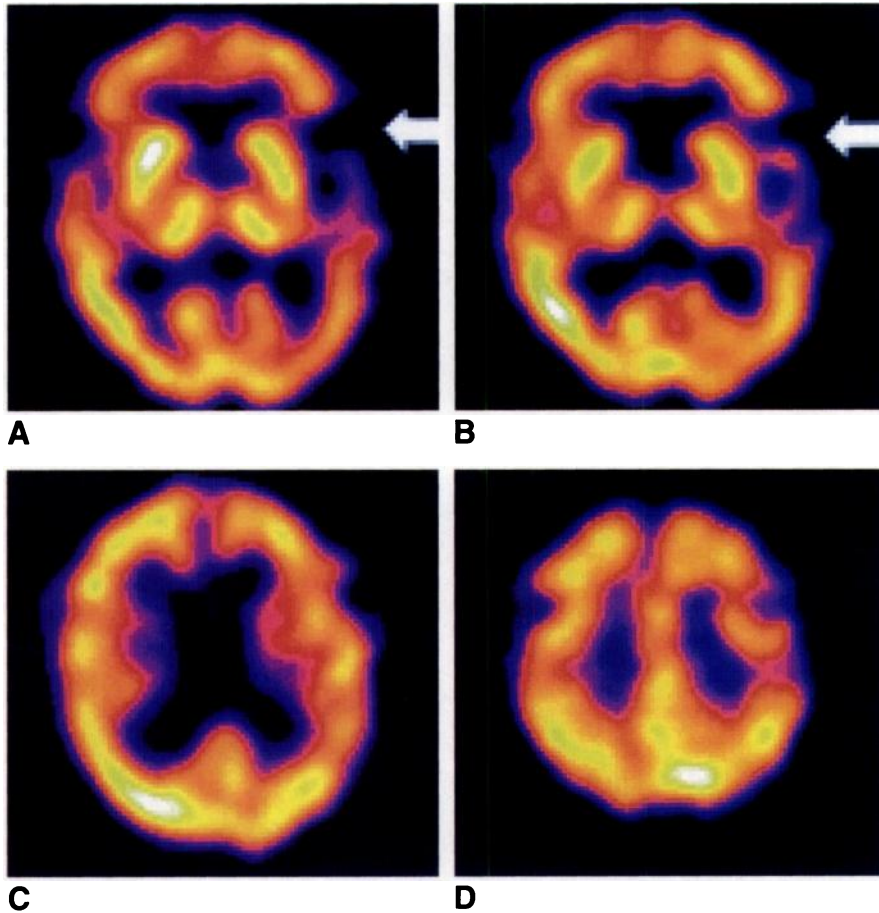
A–D, Axial SPECT images of a 61-year-old woman with unipolar depression. Focal decreased radiotracer uptake is present in left lateral frontal and temporal lobes (arrows). Remainder of brain appears normal.
